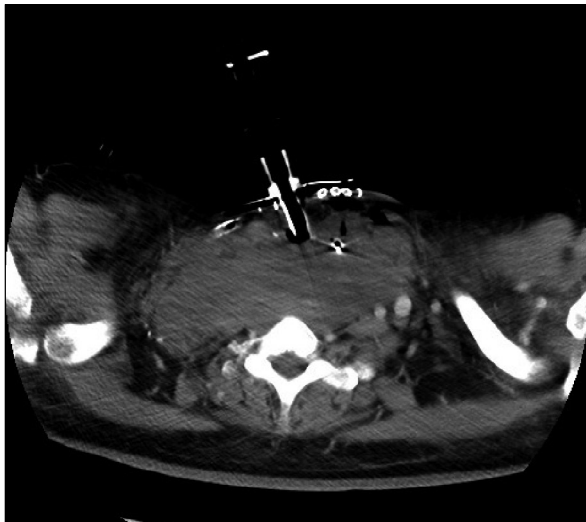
Computed tomographic scan before chemotherapy showing a huge tumour compressing the airway, vessels, and oesophagus after debulking surgery and tracheostomy
